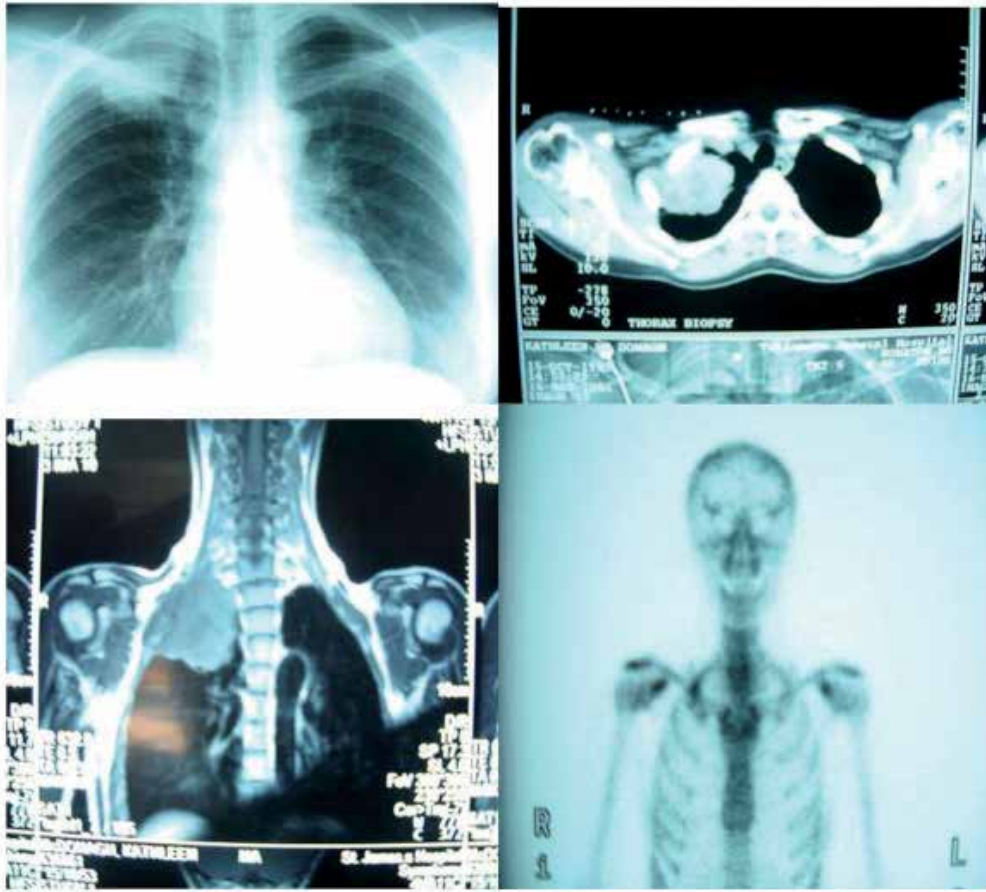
CXR, CT Chest imaging, MRI and bone scan of a Pancoast tumor of a 47 yrs old female, Ex smoker (25 cigs per day up to 13 years ago). Six weeks history of shoulder pain radiating to the median aspect of the right arm. CXR mass at apex of right chest. Percutaneous Biopsy NSCLC. PMH: Hysterectomy for Ca cervix 1996 - no evidence of recurrence. Clinical examination fullness in right supra-clavicular fossa.
